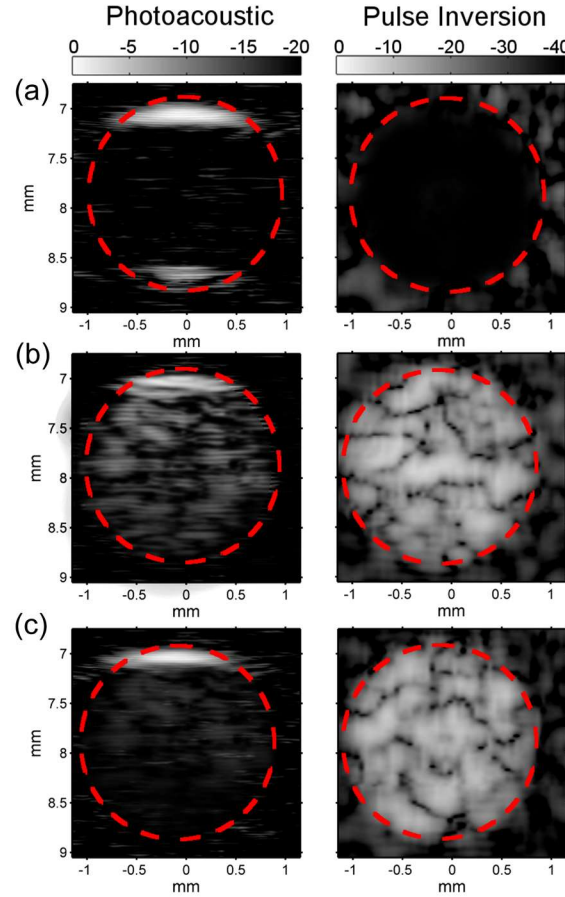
in vitro* ultrasound and photoacoustic images of AuMBs
